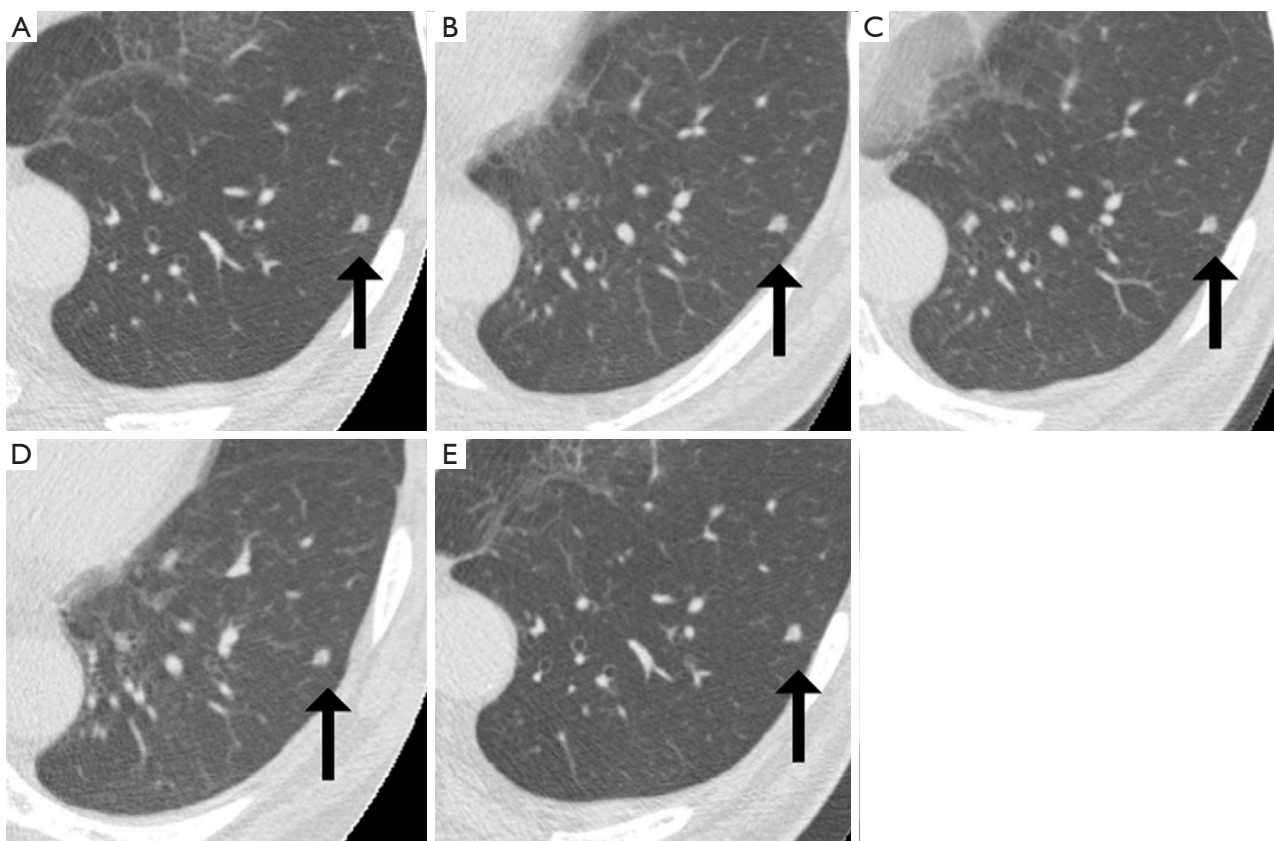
Axial chest CT images of the representative stable nodule in segment 9 of the left lower lobe. The nodule was imaged at five time points (left to right) between September 2004 and September 2009. (A) September 2004; (B) January 2005; (C) January 2006; (D) January 2007; (E) September 2009.
